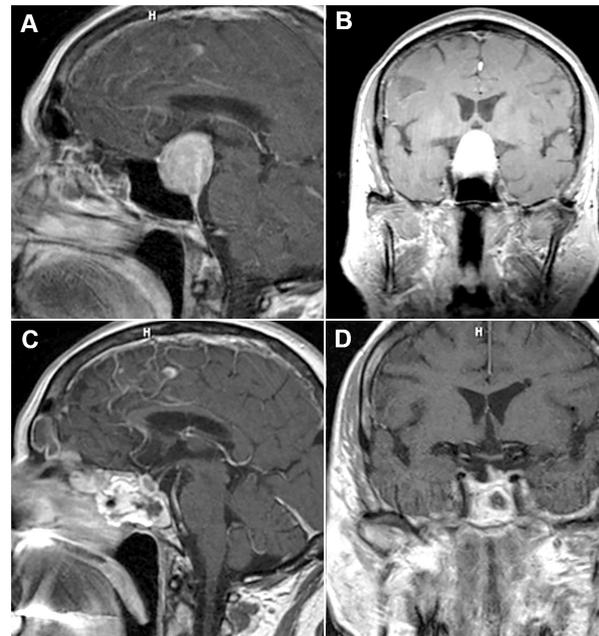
A woman in her late 70s presented with severe headache, VI nerve palsy, and visual decline. Combined transsphenoidal resection for hormone-inactive macroadenoma was performed. Preoperative (A) T1 sagittal and (B) T1 coronal post-contrast MRI of the head shows large intra, para, and suprasellar tumor with compression of optic chiasm and infiltration of cavernous sinus. Postoperative (C) sagittal and (D) coronal post-contrast T1 MRI of the head shows complete resection of the tumor with intact pituitary gland/stalk (note the fat graft in the sphenoid sinus-SS). The patient recovered fully her vision and double vision.
